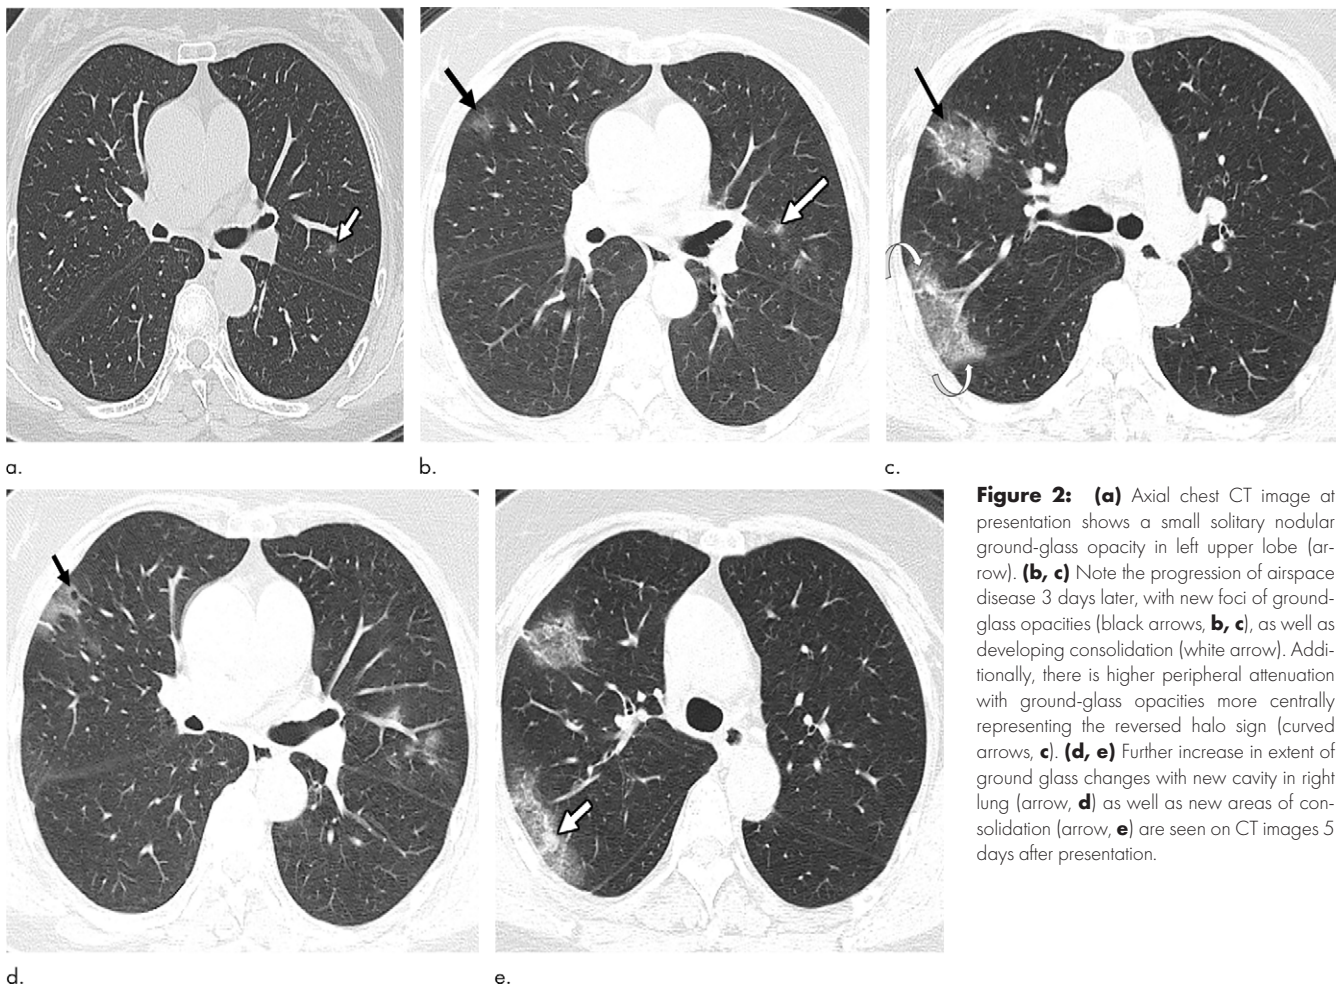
(a) Axial chest CT image at presentation shows a small solitary nodular ground-glass opacity in left upper lobe (arrow). (b, c) Note the progression of airspace disease 3 days later, with new foci of ground-glass opacities (black arrows, b, c), as well as developing consolidation (white arrow). Additionally, there is higher peripheral attenuation with ground-glass opacities more centrally representing the reversed halo sign (curved arrows, c). (d, e) Further increase in extent of ground glass changes with new cavity in right lung (arrow, d) as well as new areas of consolidation (arrow, e) are seen on CT images 5 days after presentation.
